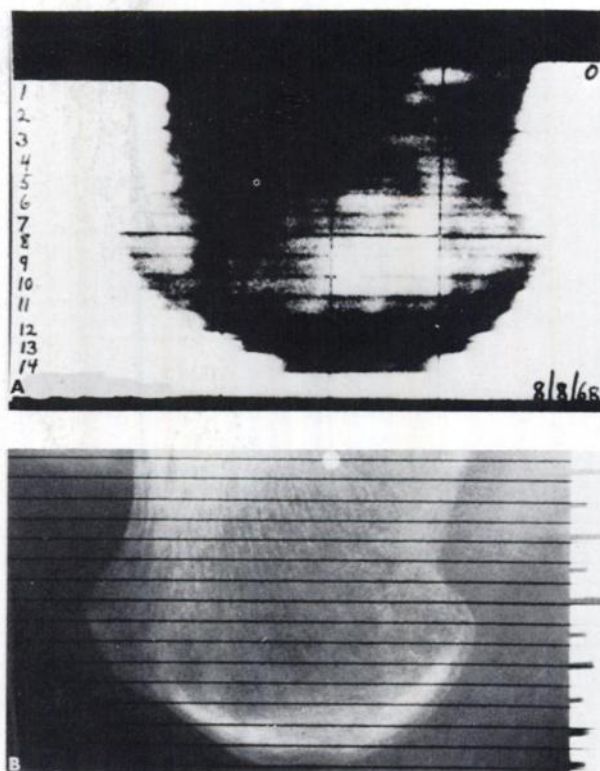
Contour display and radiograph of os calcis. A: Contour display relates degree of radiation transmissibility to intensity of dot on oscilloscope. High transmission (tissue) is white, and low transmission (bone) appears in varying degrees of grey to black, depending upon mineral content. Photograph is obtained from defocused oscilloscope screen. B: Radiograph of same area of os calcis. Superimposed lines depict sequential scan lines, spaced $\frac{1}{8}$ in. apart and relate to scan rows in contour display.
